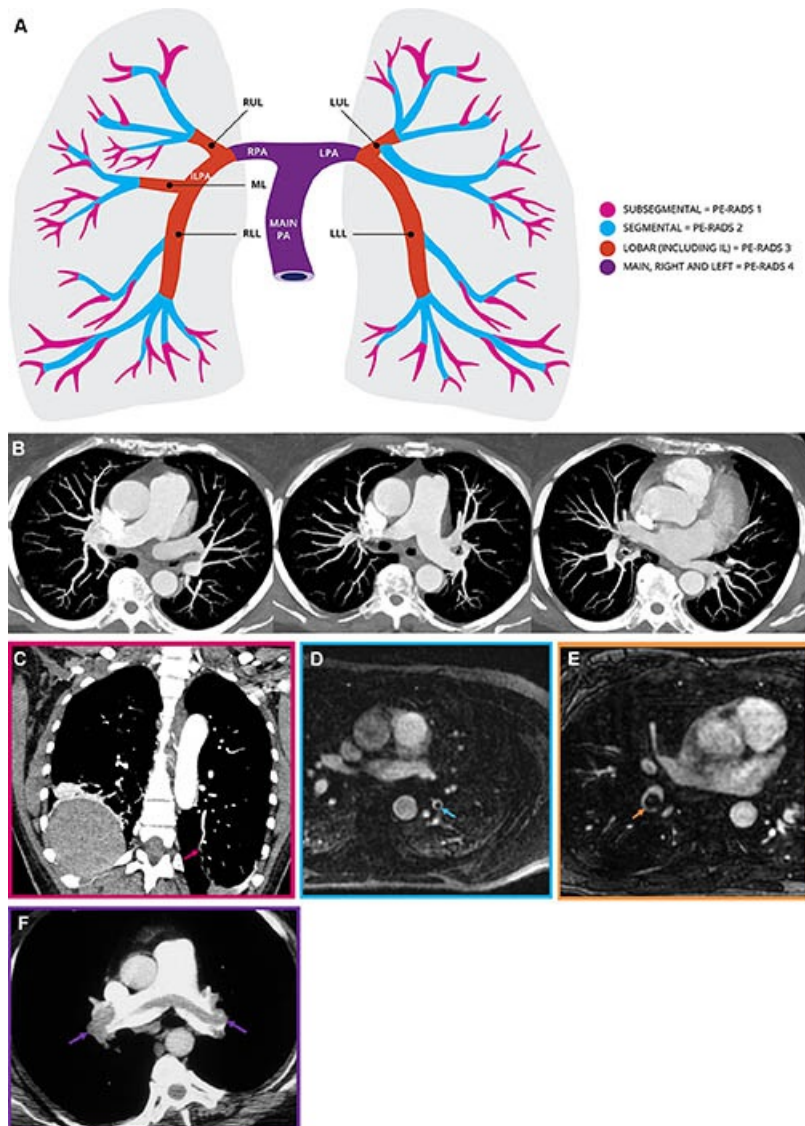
Ordinal scoring of acute thromboembolism for the Pulmonary Embolism Reporting and Data System (PE-RADS). (A) Anatomic depiction of pulmonary arterial vasculature for ordinal scoring of thrombus for PE-RADS 0–4. IL = interlobar, LLL = left lower lobe, LPA = left main PA, LUL = left upper lobe, ML = middle lobe, PA = pulmonary artery, RLL = right lower lobe, RPA = right PA, RUL = right upper lobe. (B) Pulmonary embolism (PE) chest axial CT angiography images demonstrate the absence of PE, PE-RADS 0. (C) PE chest coronal CT angiography image demonstrates acute thrombus in the right lower lobe subsegmental pulmonary artery as the most proximal location of the pulmonary embolus (arrow), PE-RADS 1. (D) PE chest axial MR angiography image demonstrates acute thrombus in the left lower lobe segmental pulmonary artery as the most proximal location of the pulmonary embolus (arrow), PE-RADS 2. (E) PE chest axial MR angiography image demonstrates thrombus in the right lower lobar pulmonary artery as the most proximal location of the pulmonary embolus (arrow), PE-RADS 3. (F) PE chest axial CT angiography image demonstrates thrombus in the main, left, and right pulmonary arteries as the most central location of the pulmonary embolus (arrows), PE-RADS 4
